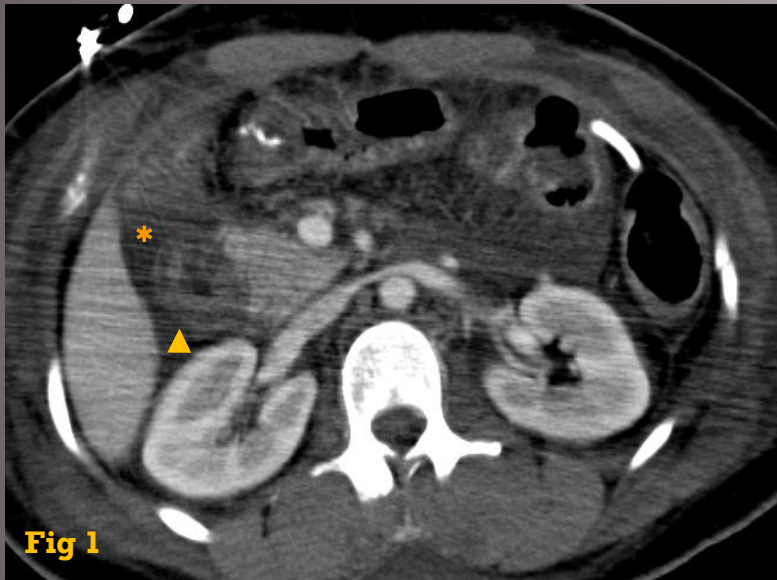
Abdominal CT of a patient who had had a car accident a week before shows duodenum contusion. The 2nd portion of the duodenum is surrounded by fluid (asterisk) and its wall presents the water-target sign (arrowhead).
